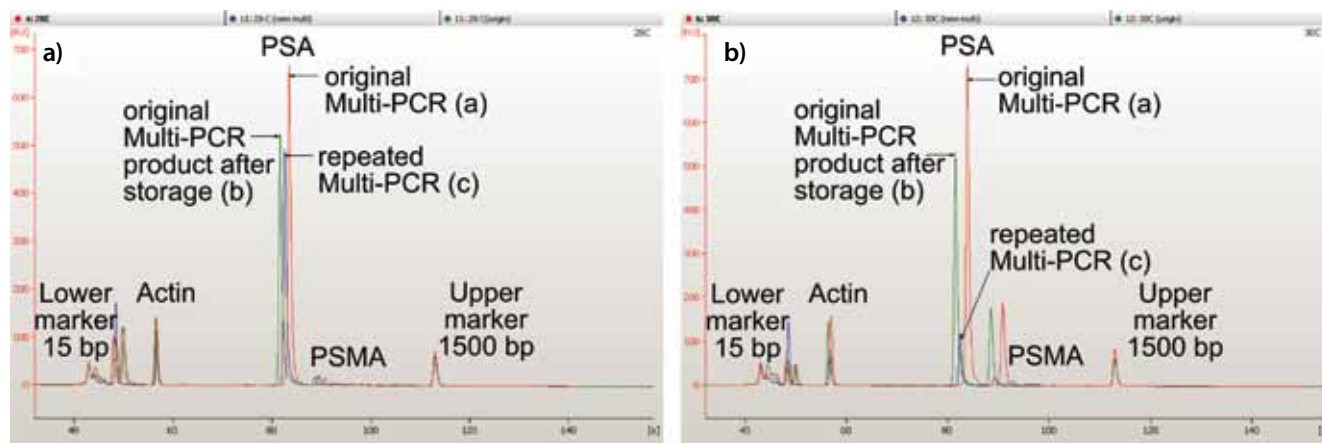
Overlaid electropherograms of two patient samples measured after the original Multi-PCR (a), the 10 months storage of original Multi-PCR product (b) and the repeated Multi-PCR (c) for two different samples. The time between the original and the second Multi-PCR/measurement was 10 months for both samples. EGFR - epithelial growth factor receptor; PSA - prostate specific antigen; PSMA - prostate specific membrane antigen.
